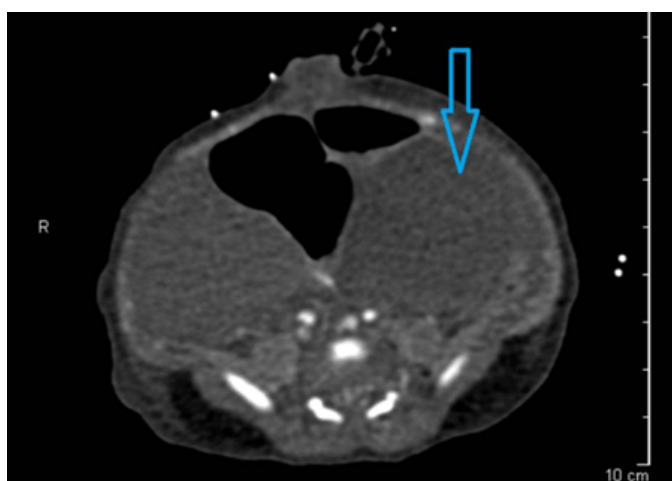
Computed tomography scan of abdomen pelvis with intravenous contrast showing extensive complex ascites (blue arrow).
